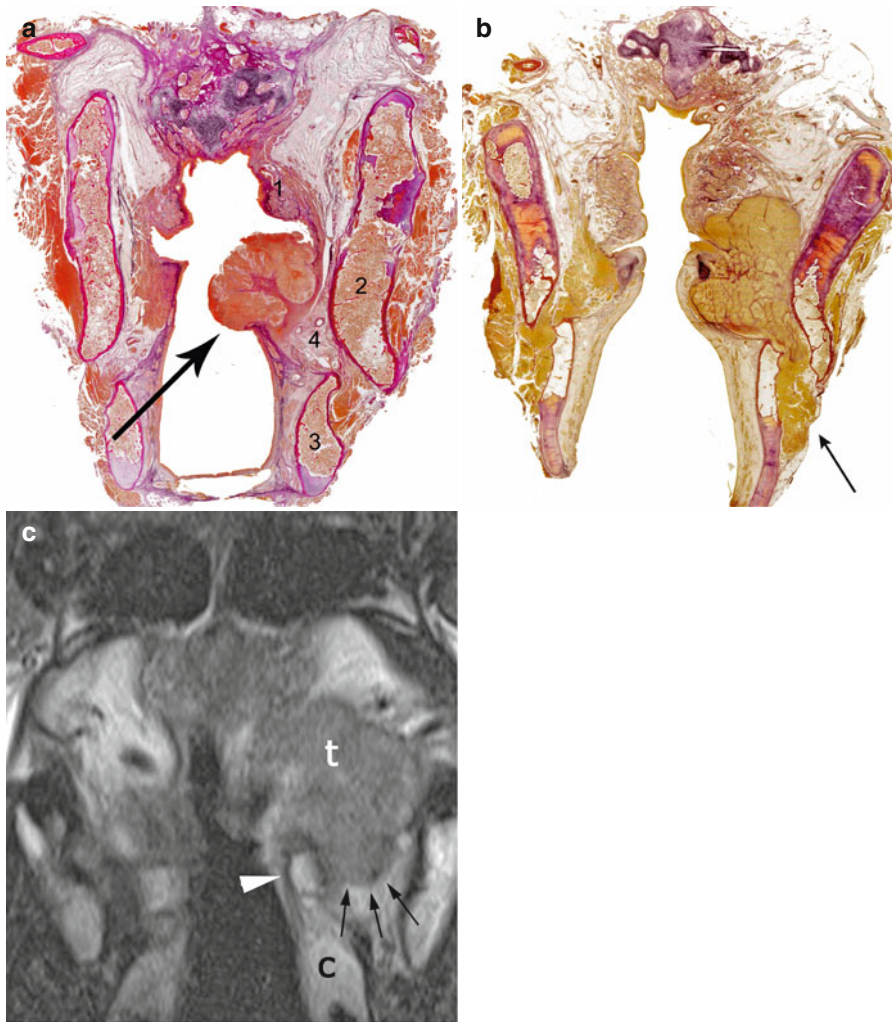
Carcinomas of the vocal cord. (a) Coronal macrosection of the larynx showing that the tumour infiltrates the vocal muscle (*arrow*), while the paraglottic space is intact (cT1 or T2, depending on cord mobility). 1 Ventricular fold, 2 thyroid cartilage, 3 cricoid cartilage, 4 inferior paraglottic space. (b) Coronal macrosection of the larynx showing infiltration of the inferior paraglottic space (*arrow*) (pT3) and, laterally, extension from the larynx through the cricothyroid space (pT4). (c) Larynx MRI: T2-weighted sequence on coronal plane. This tumour (*t*) spreads towards the infero-posterior part of the paraglottic space, between the arytenoid (*arrowhead*) and the thyroid cartilages. The tumour does not extend beyond the larynx, and the inferior boundary between tumour and paraglottic space is visible (*arrows*)
